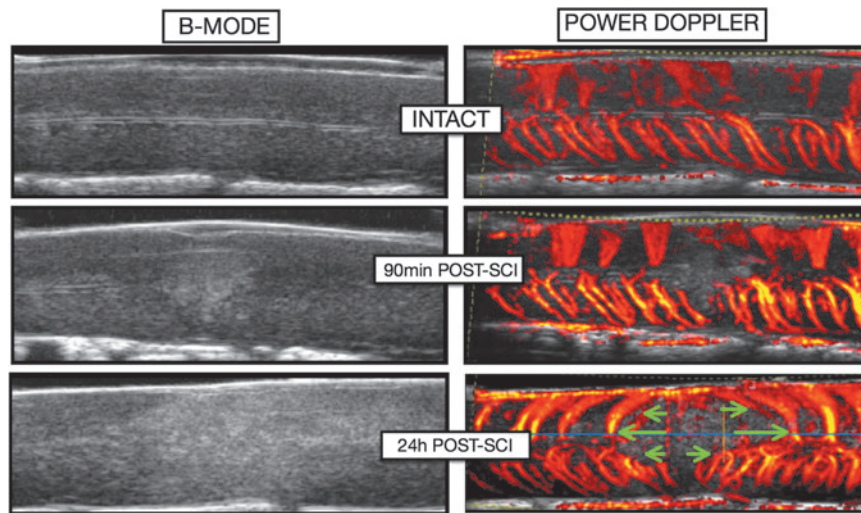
Evolution of the parenchymal lesion on B-mode and the associated vascular network changes on power Doppler mode. Immediately after spinal cord injury (SCI), a hyperechoic lesion appears in the parenchyma and several sagittal vessels located at the epicenter are destroyed and no longer generate a detectable ultrasound signal. During the 24 h after SCI, the lesion expands rostrally and caudally, pushing away the remaining sagittal vessels (green arrows). The expansion of the secondary lesion progressively destroys perilesional areas that were spared initially (i.e. secondary injury).
